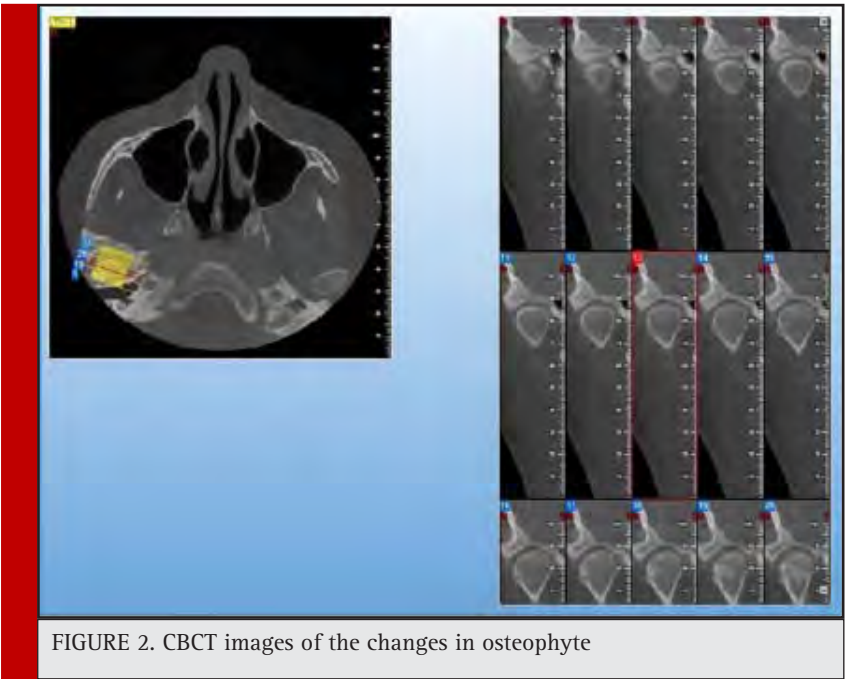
CBCT images of the changes in osteophyte
